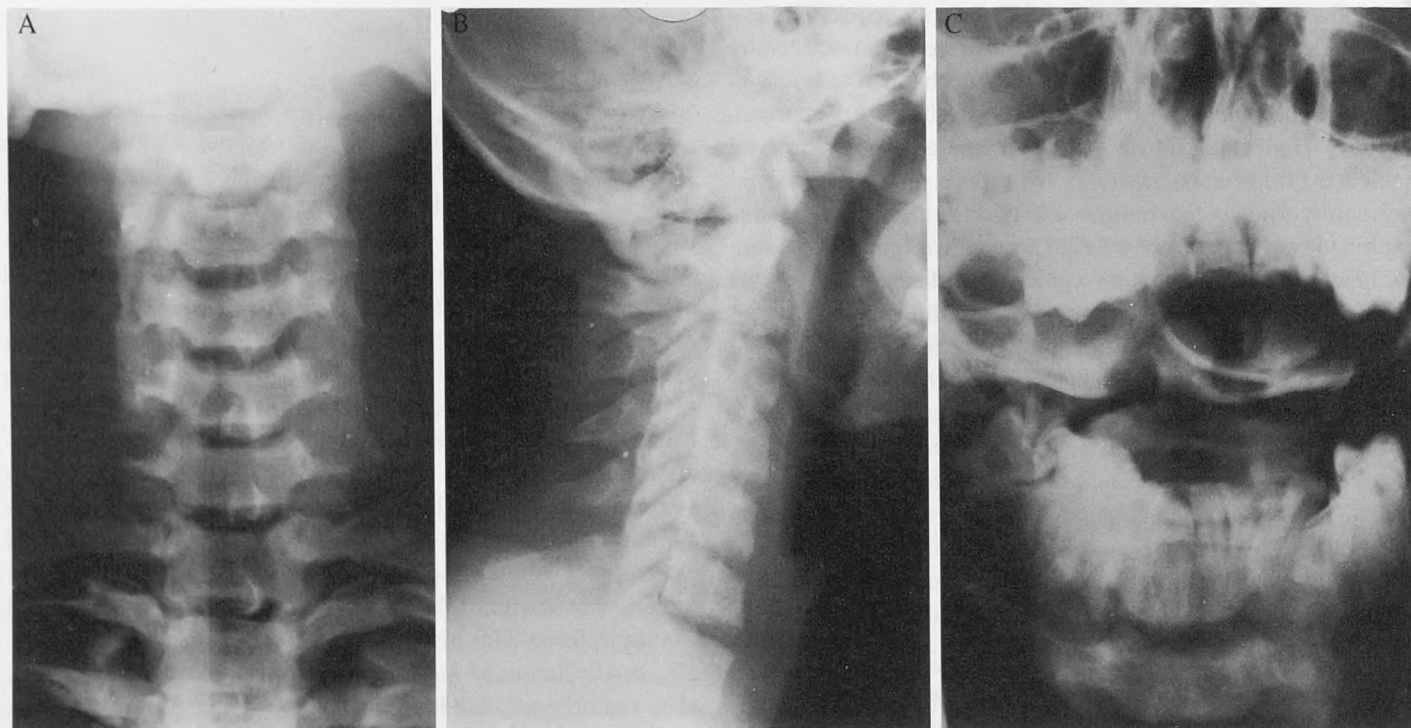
Standard radiographs of the cervical spine on the day of injury. (A) Anteroposterior projection. (B) Lateral projection. (C) Open-mouth projection. The open-mouth view is suboptimal, with the odontoid not centered between the occipital condyles. The technician was unable to obtain a better view due to muscular spasm. These films failed to reveal the fracture of C1.
